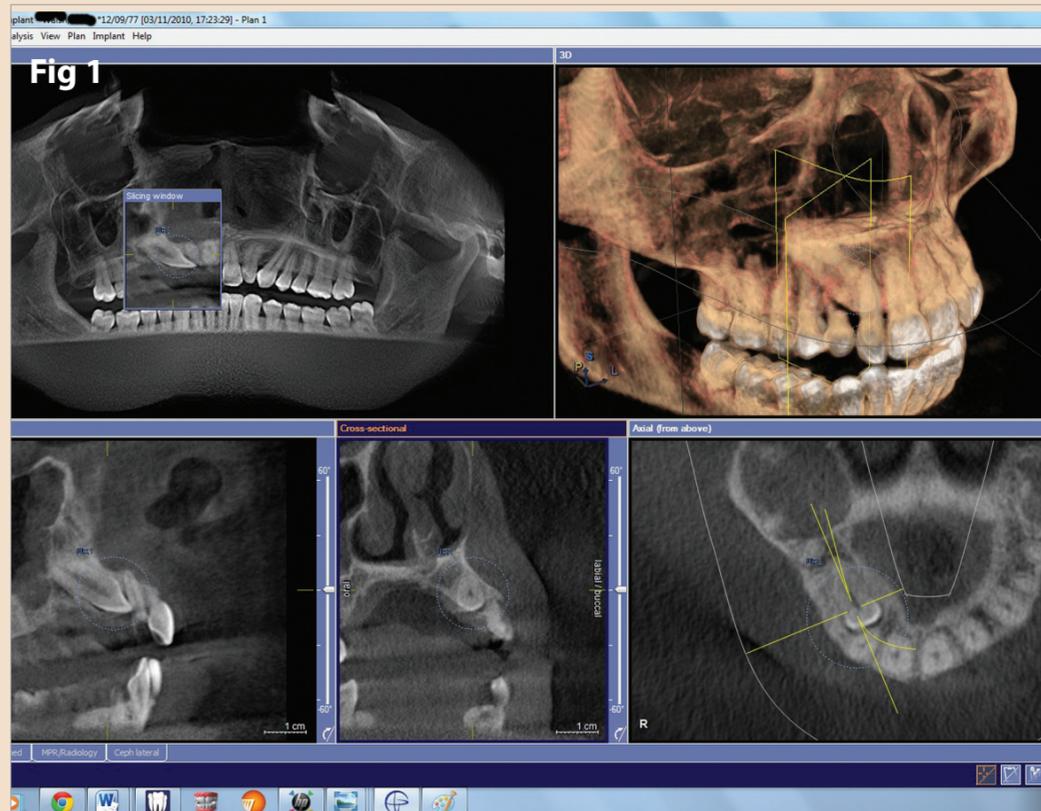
Galileos CBCT scan showing the position of the UR3
